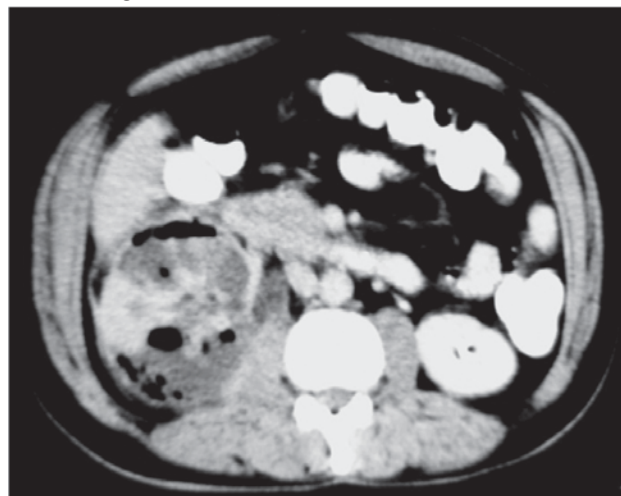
CT abdomen with contrast showing evidence of pyelonephritis involving right kidney with enlargement, multiple air pockets and heterogeneous contrast enhancement.
